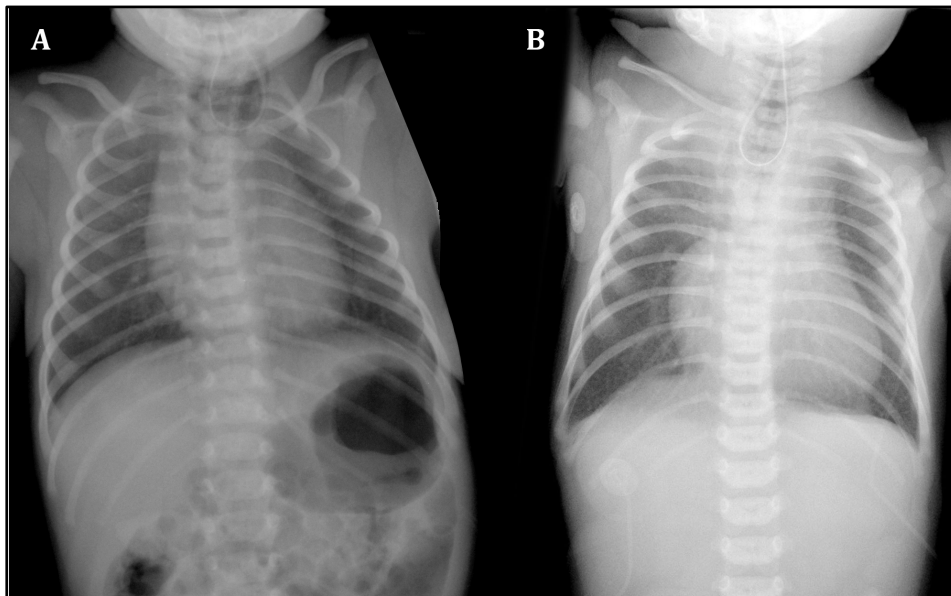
X-RAY SHOWING OESOPHAGEAL ATRESIA. A nasogastric tube is coiling in the upper pouch of the oesophagus. Presence of a gastric bubble suggests a fistula connecting the trachea with the distal tract of the oesophagus.
